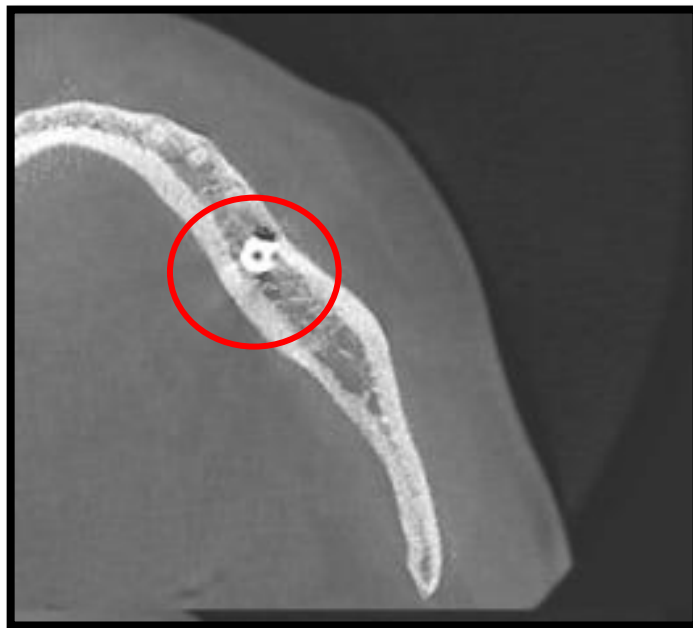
Post OP CBCT after 3 months
